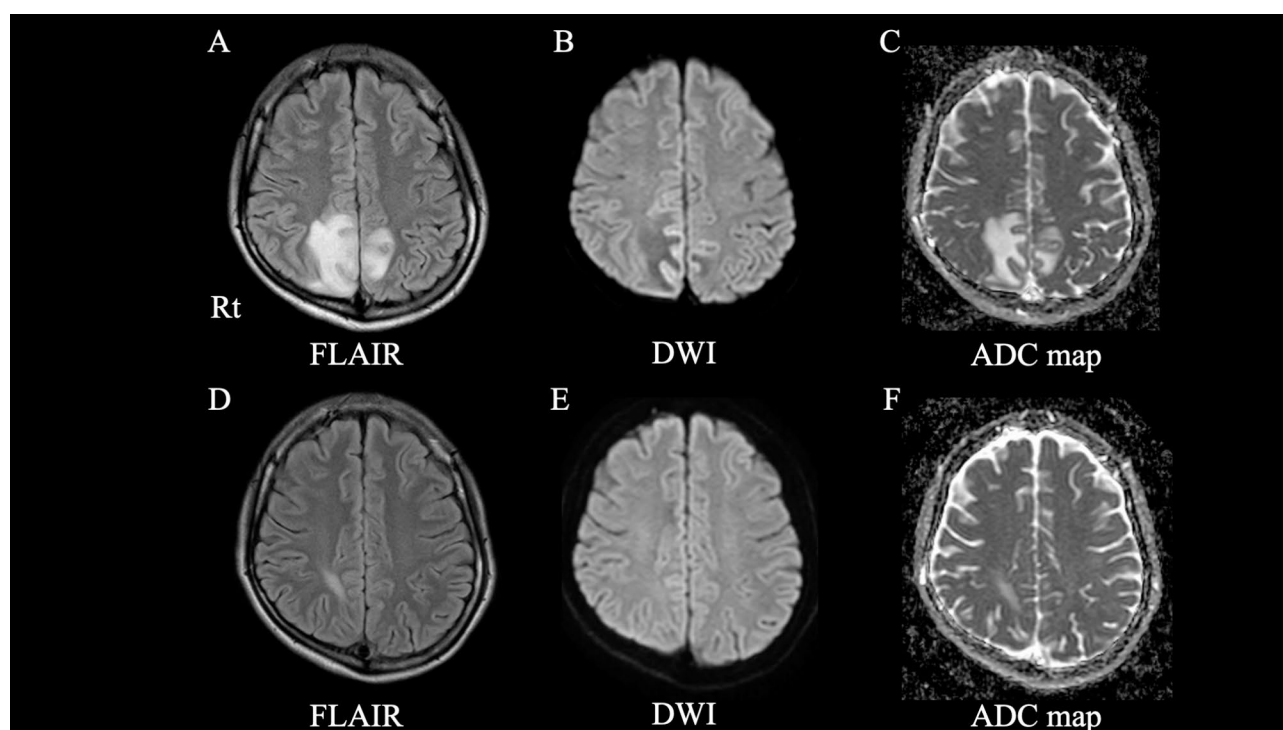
MRI findings of the patient. After an episode of generalized tonic-clonic seizures, fluid-attenuated inversion recovery imaging demonstrated high-signal lesions in her bilateral parietal and right occipital lobes on the 10th day of hospitalization (A). The diffusion-weighted image (DWI) (B) and apparent diffusion coefficient (ADC) map (C) showed high ADC lesions in her bilateral parietal and right occipital lobes, suggesting T2 shine-through lesions and small-sized diffusion-restricted lesions in her parietal lobes. Follow-up MRI revealed shrinkage of the lesions on the 25th day of hospitalization (D, E, F)
